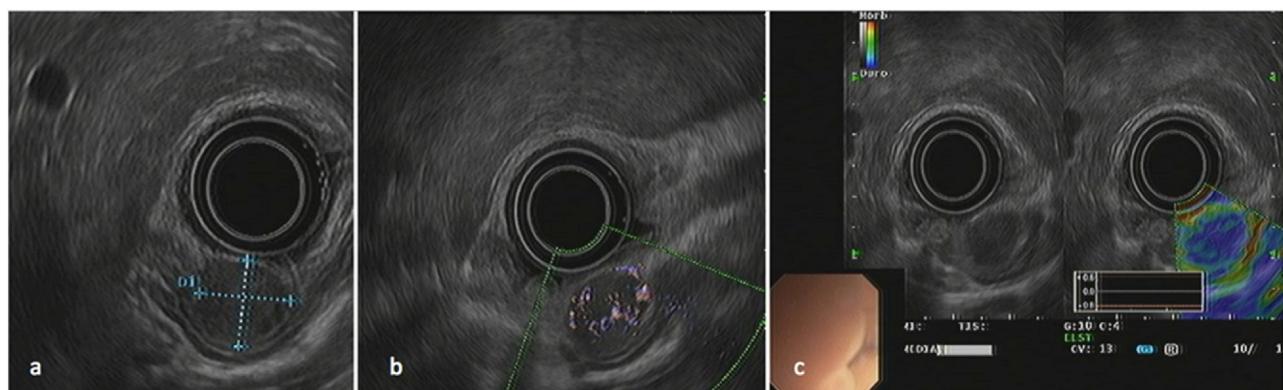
Endoscopic ultrasonography view of the gastric lesion, showing a round lesion, with definite margins, homogeneously hypoechoic (a) with visible internal vascularization (b), a hard texture at elastography (c), measuring 10 mm × 9 mm. The lesion originated from the submucosal layer (3rd layer) of the stomach with no involvement of the other layers of the gastric wall (a).
